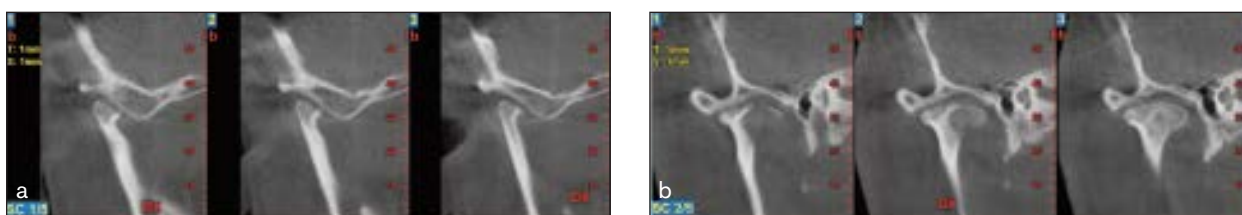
CBCT images of a TMJ of a patient without a RDC/TMD diagnosis but with bony osteoarthritic changes (erosions and osteophyte). (a) Sagittal. (b) Coronal.
